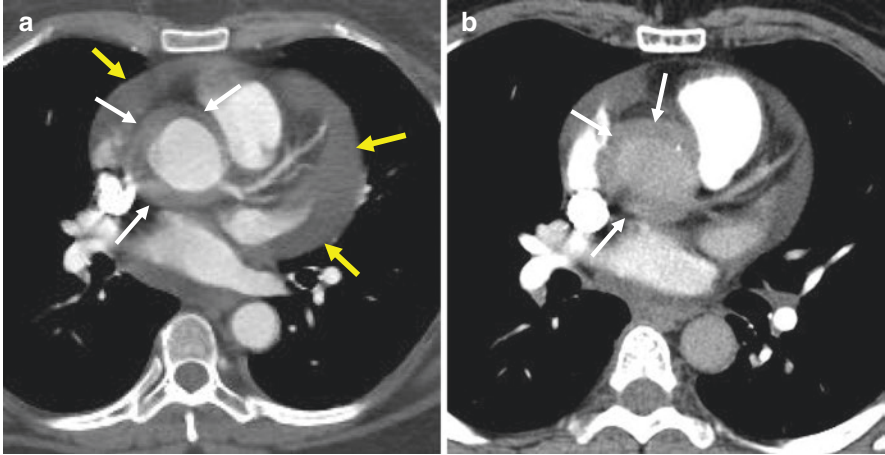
Aortitis of the ascending aorta seen on abdomen CT (a) and unchanged 4 months later (b). Images demonstrate near circumferential thickening of the ascending aorta. This appearance may be indistinguishable from type A IMH at imaging and careful history and clinical examination must be undertaken to help differentiate the two entities. A small pericardial effusion present on the first study has essentially resolved by the second
